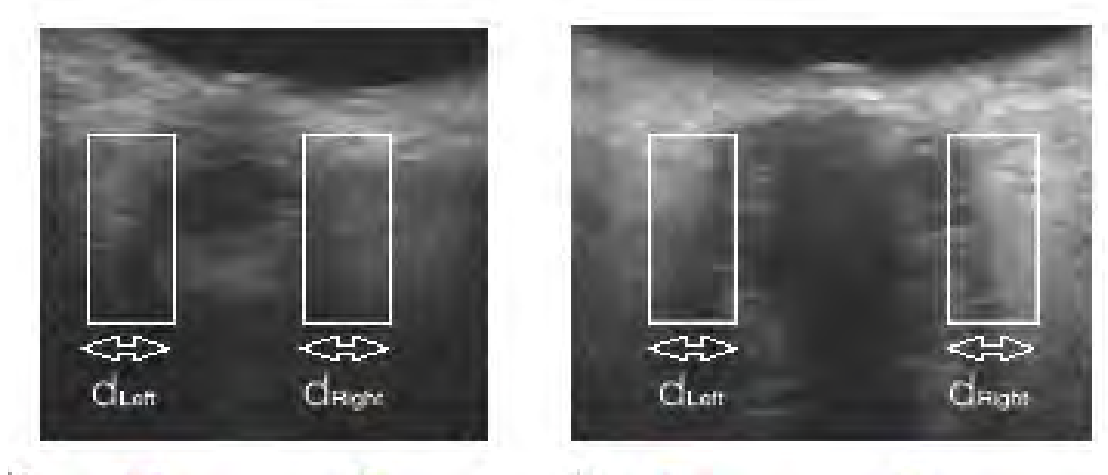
Transorbital ultrasound images magnified, demonstrating d_{Left} and d_{Right} .
